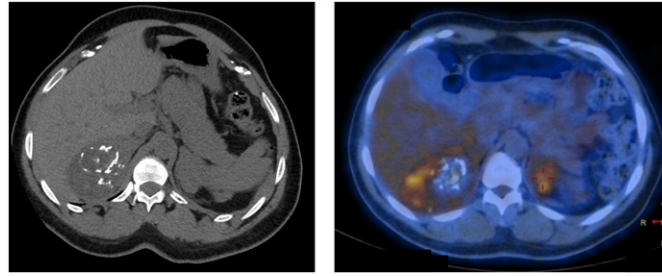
(Left) Adrenal CT scan showing large asymmetric bilateral adrenal masses. Multiple calcifications are present in the right adrenal tumor. (Right) ^{18}F -FDG-PET scan showing a mild bilateral hypermetabolism evaluated with an SUV_{max} of 5.2. The adrenal to liver SUV_{max} ratio is 1.8.
